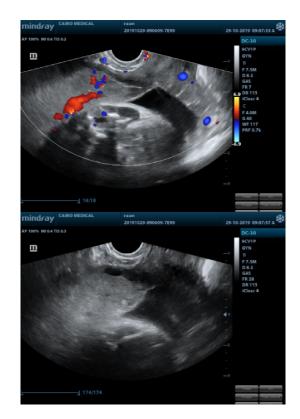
Ultrasound imaging of case 4
